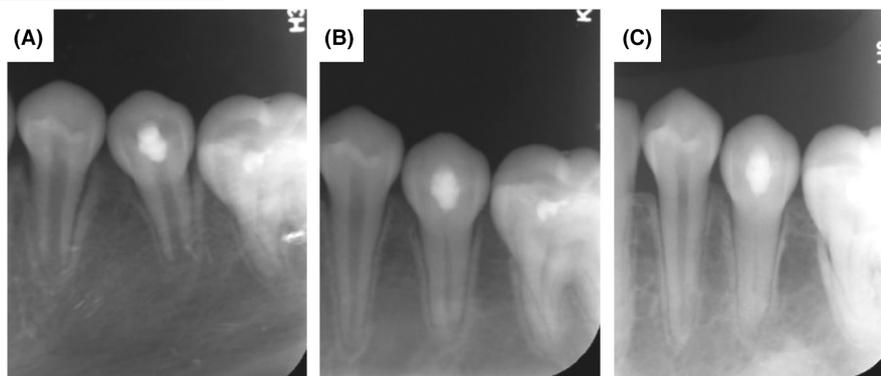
An 11-year-old female patient diagnosed with symptomatic apical periodontitis. Periapical films of tooth 35 over a 90-month follow-up duration. (A) A postoperative periapical film showing an incompletely developed root with an open apical foramen. (B) A 20-month follow-up periapical film: the root achieved complete development. (C) A 90-month follow-up periapical film: diffuse calcification occurred, and root canal images were still visible but significantly narrower.
